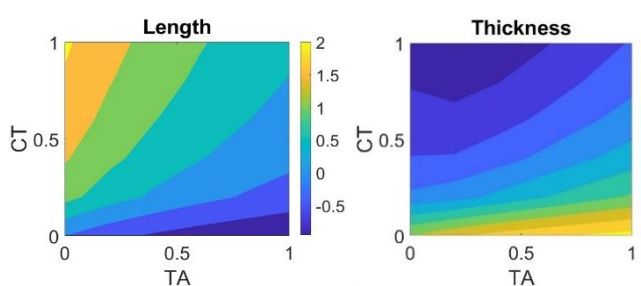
The variation of the vocal fold length and vertical thickness relative to the baseline condition in response to CT and TA activations.
